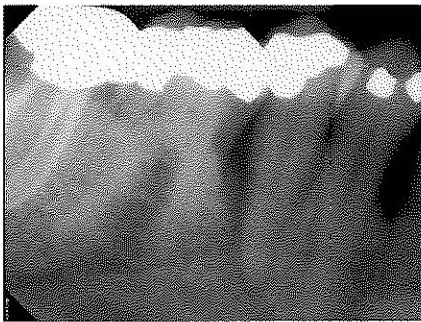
Mandibular right first and second premolar with radiographic evidence of intrabony defects
